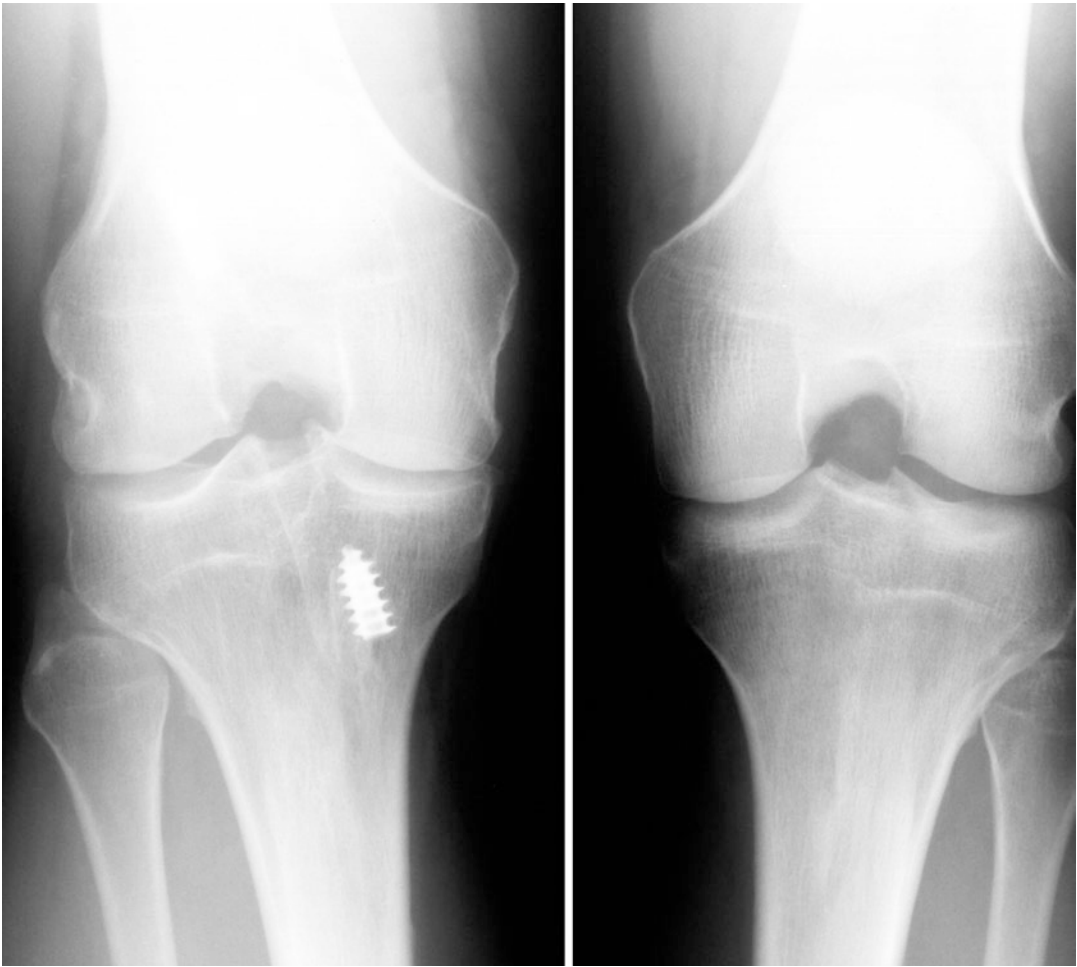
Standing radiographs of a patient 14 years after a right ACL reconstruction and subsequent medial meniscectomy. The pivot-shift test was negative, indicating a stable reconstruction. However, narrowing to the medial tibiofemoral compartment is evident and the patient demonstrated 2° of varus alignment. (Reprinted from Noyes
